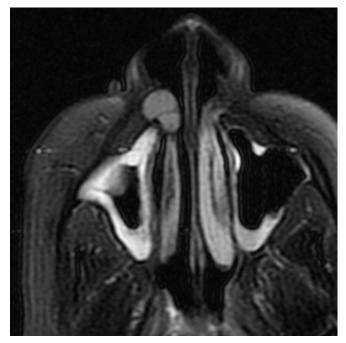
Axial T2FS magnetic resonance image of a mildly hyperintense cyst occurring in the characteristic location of a nasolabial cyst.
